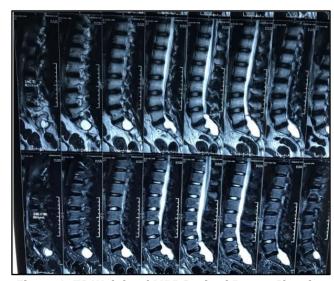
T2 Weighted MRI Sagittal Image Showing the Hyperintense Cystic Lesion in the L5-S Region
